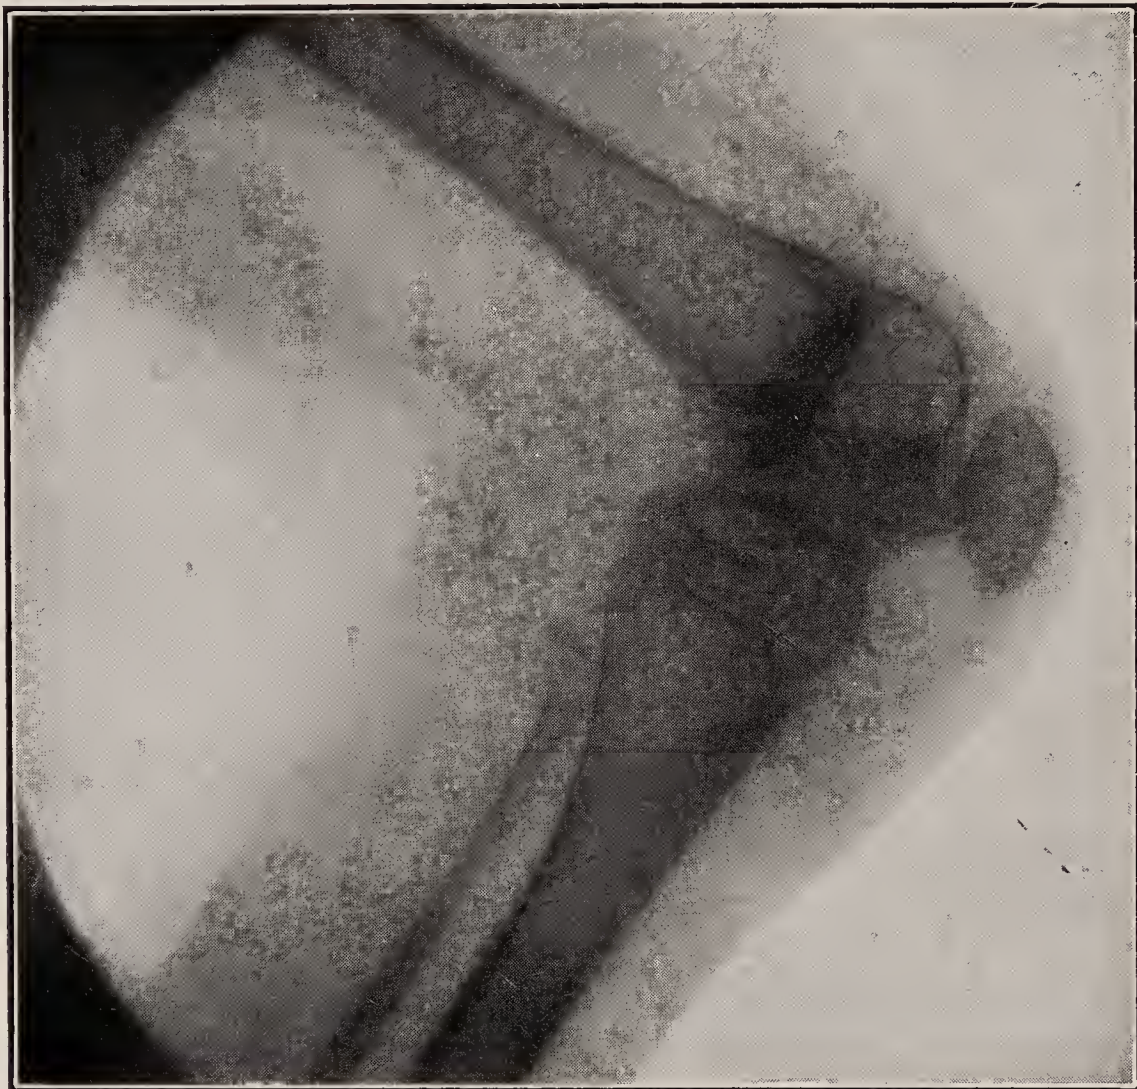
X-ray of tuberculosis of the knee joint with flexion deformity, showing beginning subluxation and beginning bone destruction.
